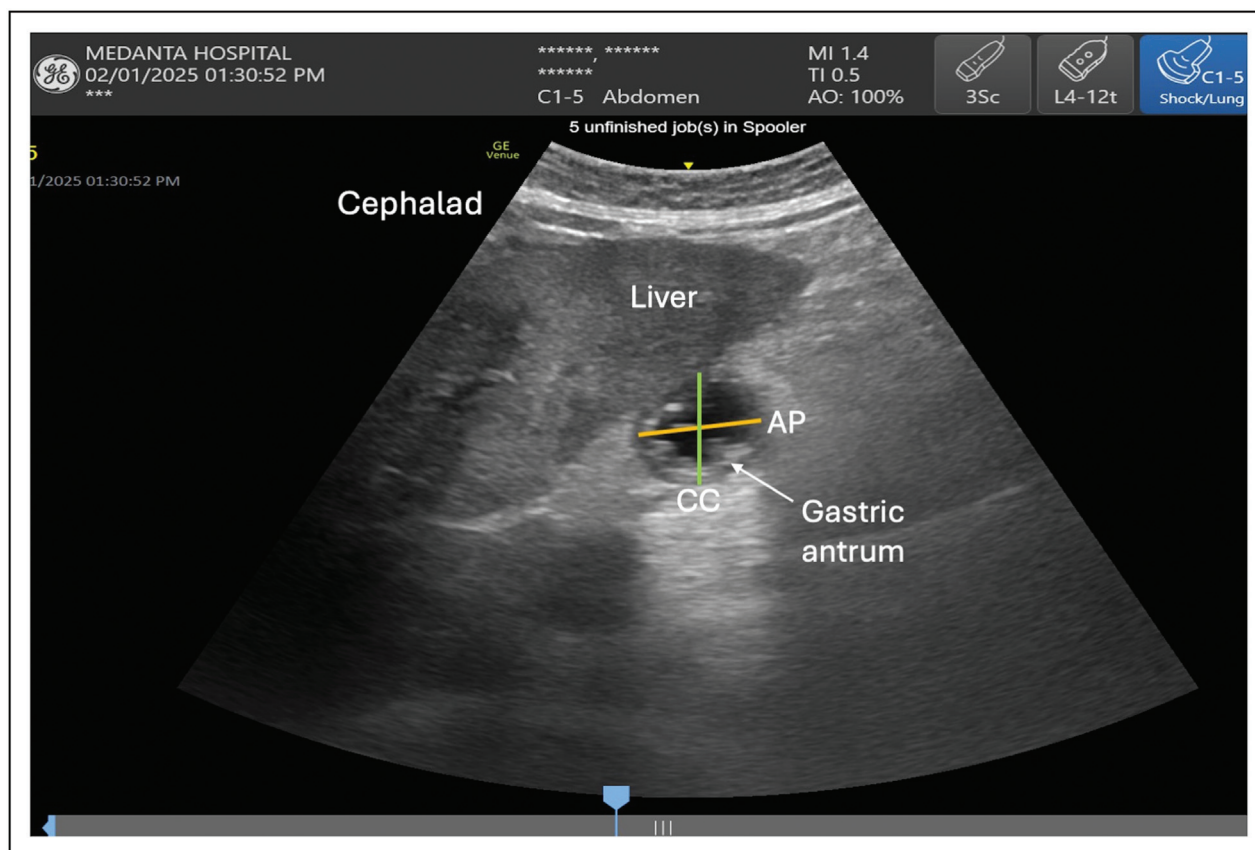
Gastric residual volume calculation. Antral cross-sectional area (ACSA; cm^2) = $(AP \times CC \times \pi)/4$, GRV (ml) = $27 + 14.6 \text{ ACSA} - 1.28 \times \text{age (years)}$. AP, anteroposterior diameter; CC, craniocaudal diameter. From Perlas A, *et al.* Validation of a mathematical model for ultrasound assessment of gastric volume by gastroscopic examination. *Anesth Analg.* 2013;116:357–363.
